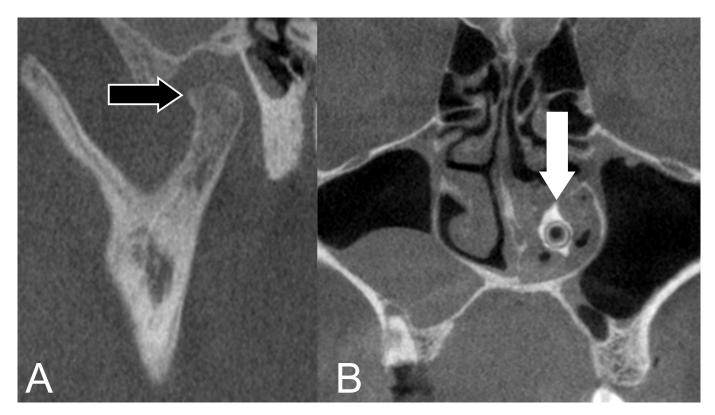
Representative cone beam computed tomography (CBCT) findings of temporomandibular joint and nasal cavity. (A) In the sagittal CBCT image, the arrow indicates the osteophyte of the condyle. (B) In the coronal CBCT image, the arrow indicates the rhinolith in the left nasal cavity.
